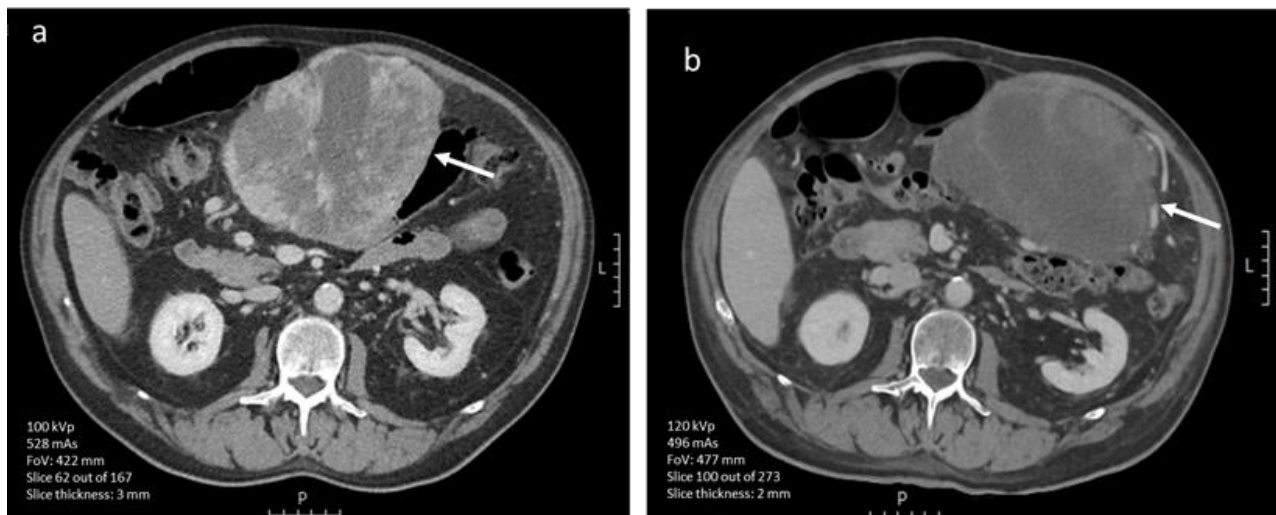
(a-b). Axial portal venous phase CT images (iodinated contrast media) of a 67-year-old male diagnosed with a primary GIST (arrows) of the stomach. (a) Pre-treatment imaging shows a large gastric mass with heterogeneous enhancement. (b) After 1.5 months of avapritinib treatment, the lesion has become hypodense (scale bars 5 cm).
